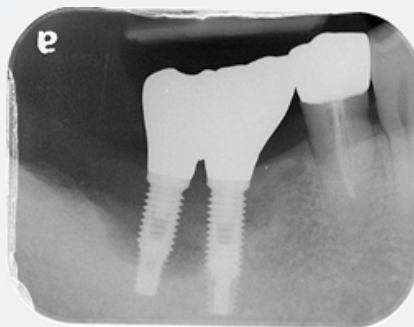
Periapical radiograph of the final restoration. Note that the grafted bone was preserved over the implant platform without significant bone resorption.
